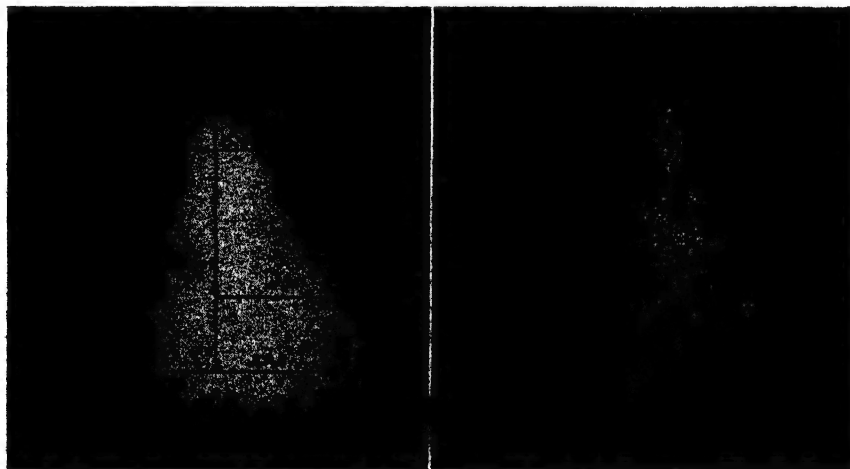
X-ray of Patient suffering from Vitamin B₁ Deficiency, before and after 10 days after Treatment. Measurements in centimetres. The patient was an alcoholic taxi-driver living largely on snacks, who had swollen and painful legs, and tingling of the fingers. The condition became worse and the patient had an attack of delirium tremens with tremors, over-activity, hallucinations and disorientation. On examination the heart was enlarged, knee and ankle jerks were absent, muscle weakness and tenderness were present in the arms and legs, which showed pitting oedema. There was a high-pitched blowing systolic murmur, gallop rhythm and enlarged liver. The first X-ray shows enlargement of the heart to right and left. The second X-ray, showing return of the heart to normal size, was taken 10 days later, after daily injections of 12 mg. vitamin B₁ and yeast orally.
